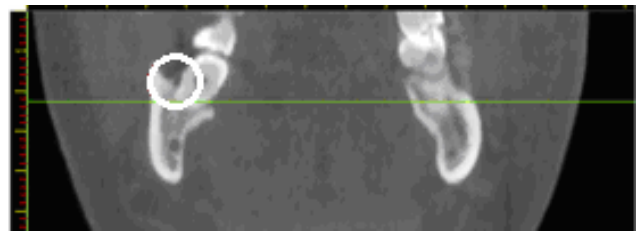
Presence of periodontitis in a given CT DICOM.
